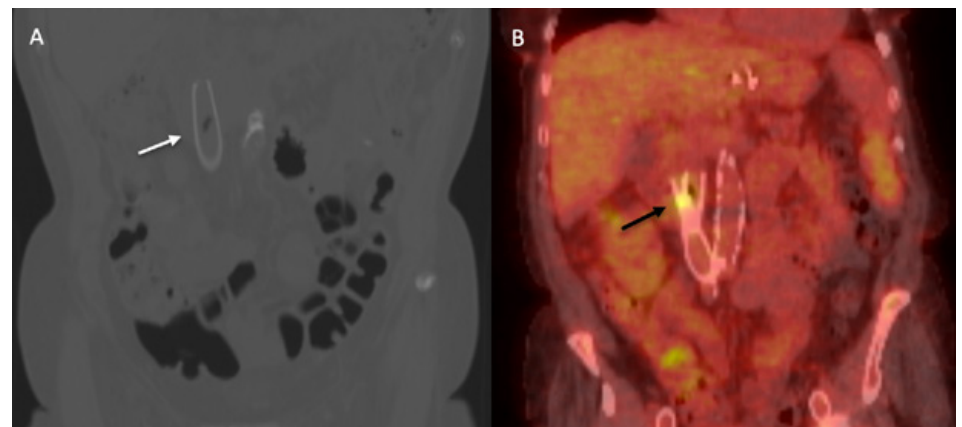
A. Computed Tomography (CT) Scan with intraluminal gas near inferior vena cava (IVC) stent. B. Positron emission tomography (PET) CT Scan with increased uptake in the area of the inferior vena cava (IVC) stent.
